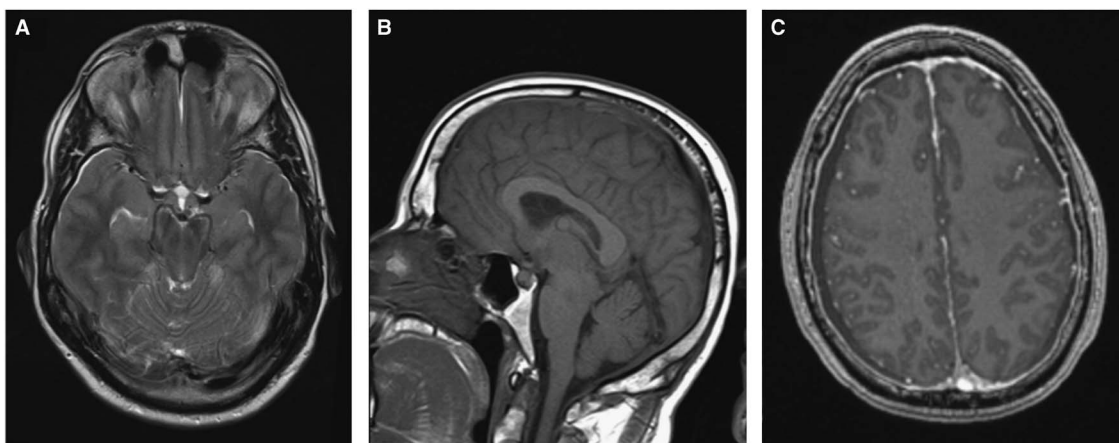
(A) MRI head (axial T2 sequence) shows effacement of perimesencephalic cisterns and suprasellar cistern from sagging brain. (B) MRI head (sagittal T1 sequence) shows mild sagging of the brain with effacement of the suprasellar and prepontine cisterns. (C) MRI head (post-gadolinium axial T1 sequence) shows diffuse dural enhancement, engorged cortical veins, and symmetric bilateral subdural hygromas.
